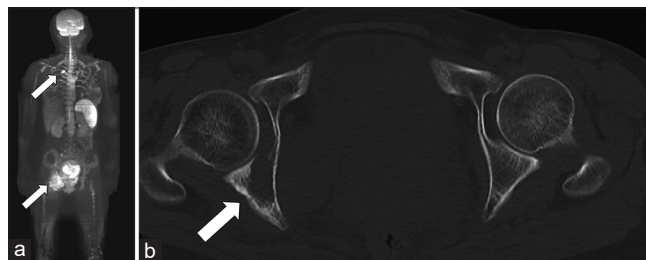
Position emission tomography (PET) and computed tomography (CT) images before pregnancy. (a) PET before pregnancy, metastatic lesion in right lung and right ischium (white arrow). (b) CT just before pregnancy, lytic lesion (white arrow)
